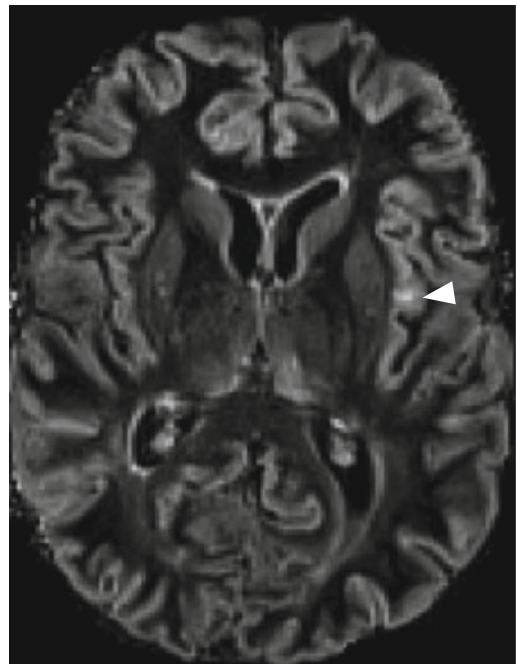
Double inversion recovery magnetic resonance image revealing a multiple sclerosis plaque on the left insular cortex (arrow)
